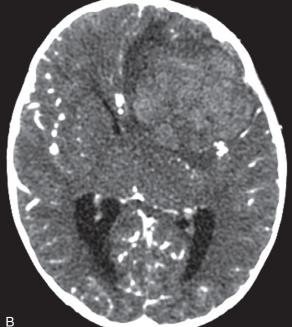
Patient presenting with seizure. A, Unenhanced CT at the level of the temporal horns of the lateral ventricles delineates a large, hyperdense, left frontal lobe intraparenchymal hematoma. Significant mass effect and dilatation of the right temporal horn/obstructive hydrocephalus are visible. B, Contrastenhanced examination performed on the same day shows marked relative hypoattenuation of the hematoma.
